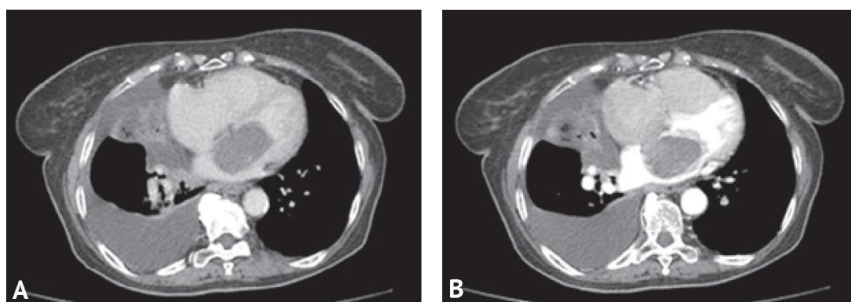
Computed tomography (A — without contrast; B — with contrast) of the chest. A large myxoma of the left atrium obstructs the left atrioventricular opening; there is a right-sided hydrothorax
